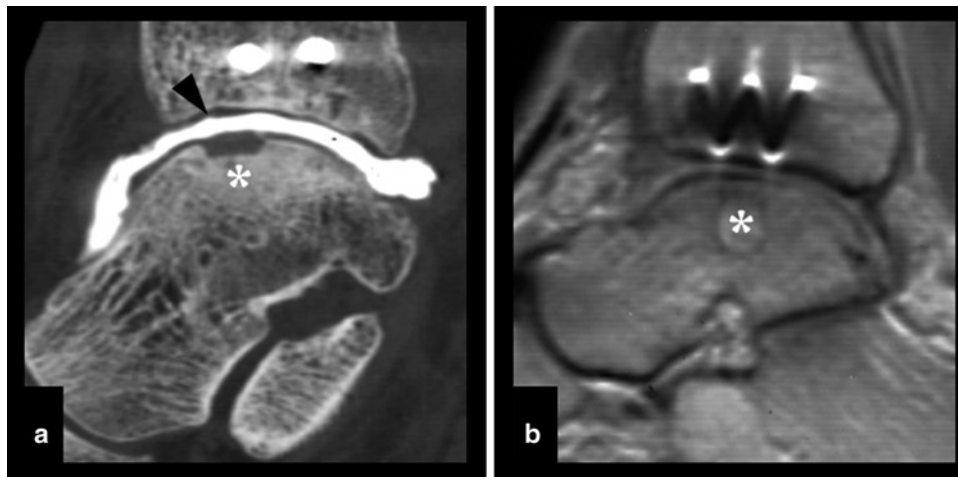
(a, b) Forty-year-old man with a history of traumatic osteochondral lesion of the talus, treated with osteochondral graft. (a) The follow-up computed tomographic (CT) arthrography of the ankle shows the osteochondral graft (asterisk) covered by continuous fibrocartilaginous
